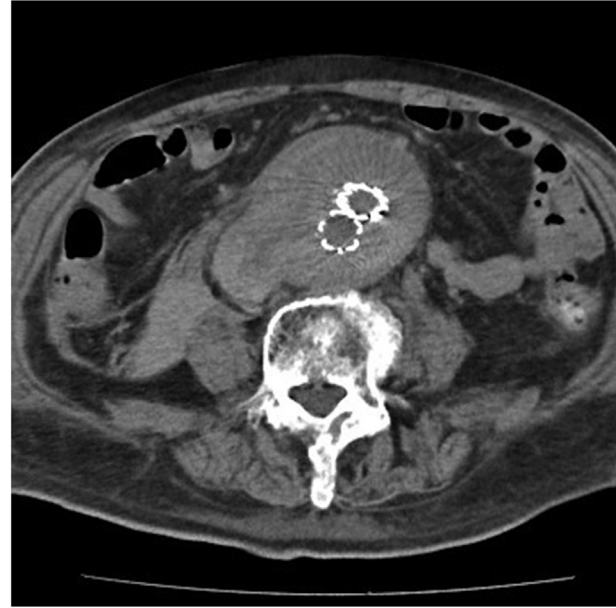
CT on fifth day after EVAR showed that the peritoneal haematoma had decreased in size.
